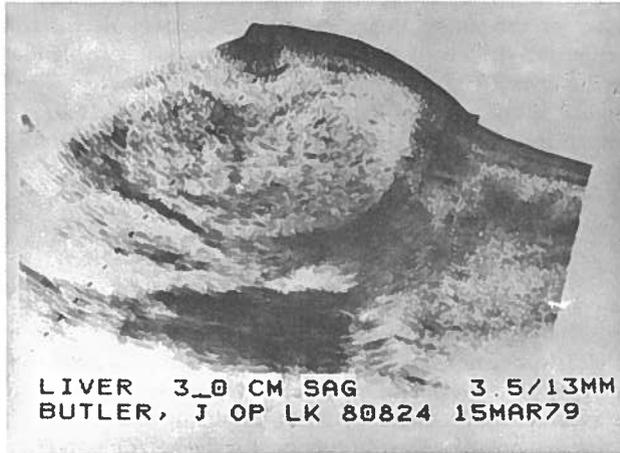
Hepatic ultrasound—An oval complex mass of about 10 cm on greater diameter with some echoes and some cystic compound
